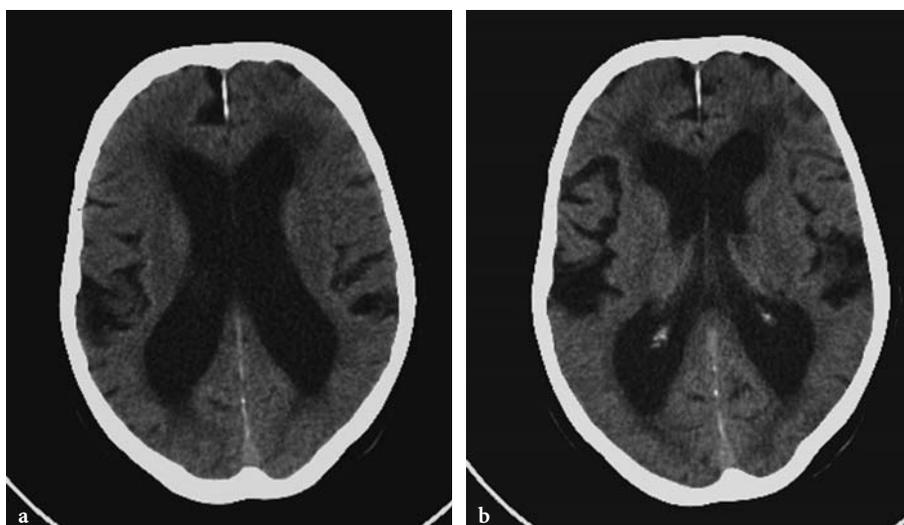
Follow-up brain CT study at low dose ($CTDI$ of 30.6 mGy) in a 79-year-old woman with (normal pressure) hydrocephalus. Low-dose axial CT images are of sufficient quality to compare the dilatation of both lateral ventricles (a and b) with previous CT studies. Calculated effective dose of low-dose CT exam is 1.05 mSv; $DLP = 405$ mGy-cm
